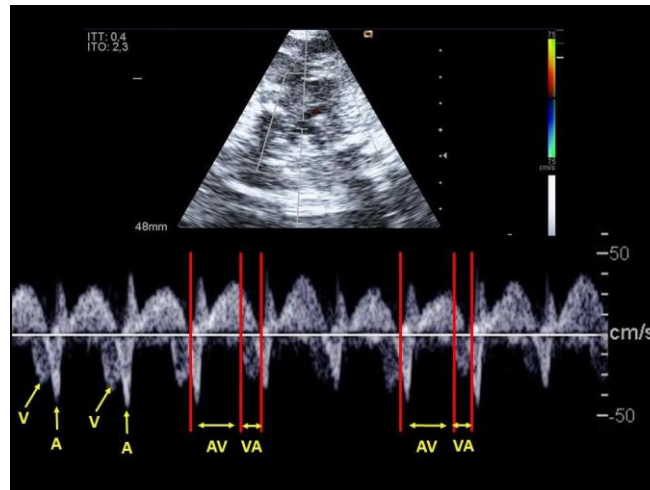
Fast pathway AVRT (short VA interval). Pulsed Doppler at the level of the superior vena cava - ascending aorta, where superior vena cava A wave of the end aortic V wave are observed. AV and VA intervals are measured, observing a shorter VA interval than the AV interval (short VA).
